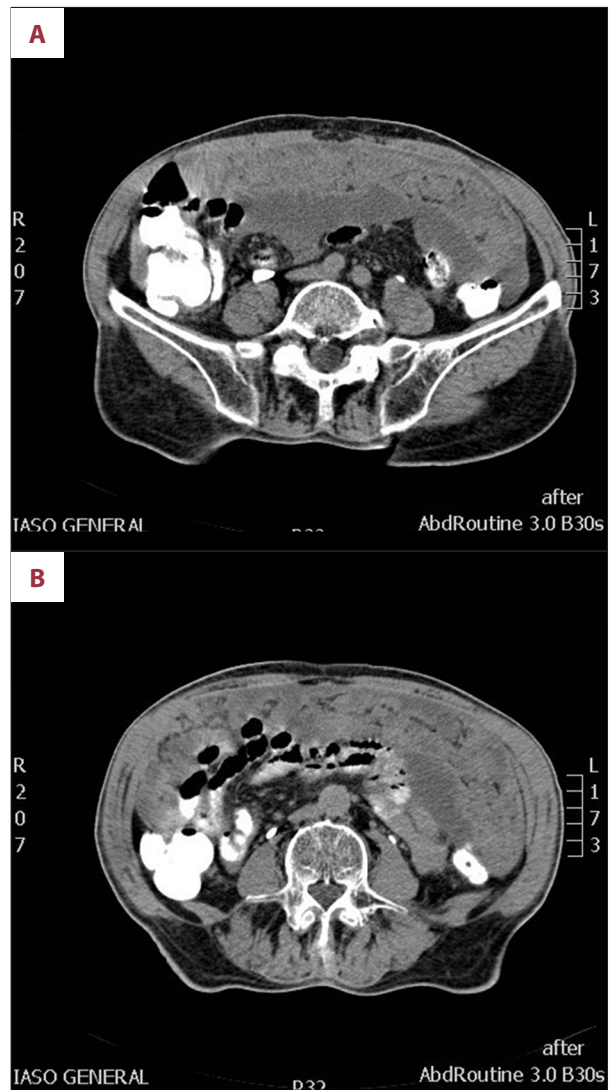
(A, B) CT scan revealing nodular peritoneal implants and mucinous ascites, indicative of pseudomyxoma peritonei. Note that the appendix is not recognized.
